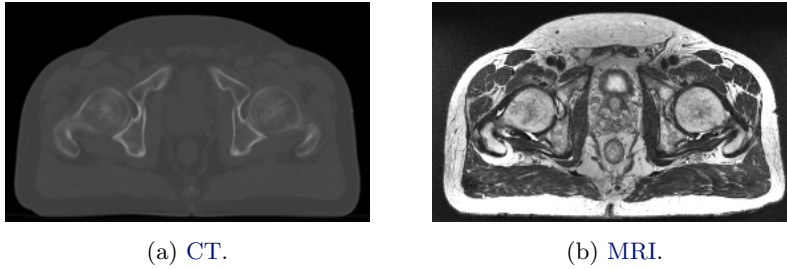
Comparison of axial CT (a) and T2 weighted MRI (b).
